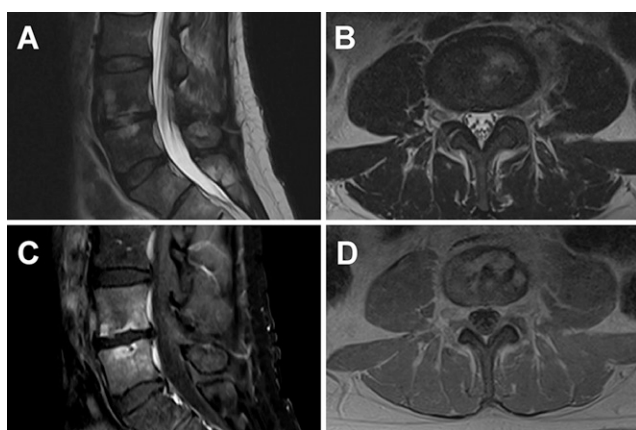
MRI sequences of known L4–5 discitis osteomyelitis. A and B: T2 hyperintensity of the L4 and L5 vertebral bodies from sagittal and axial views were overall stable compared with MRI from earlier in the initial hospital course. C: Postgadolinium T1-weighted sagittal view demonstrated adjacent involvement of the inferior L4 and superior L5 endplates. D: Axial slice of the inferior L4 endplate demonstrating contrast enhancement.
